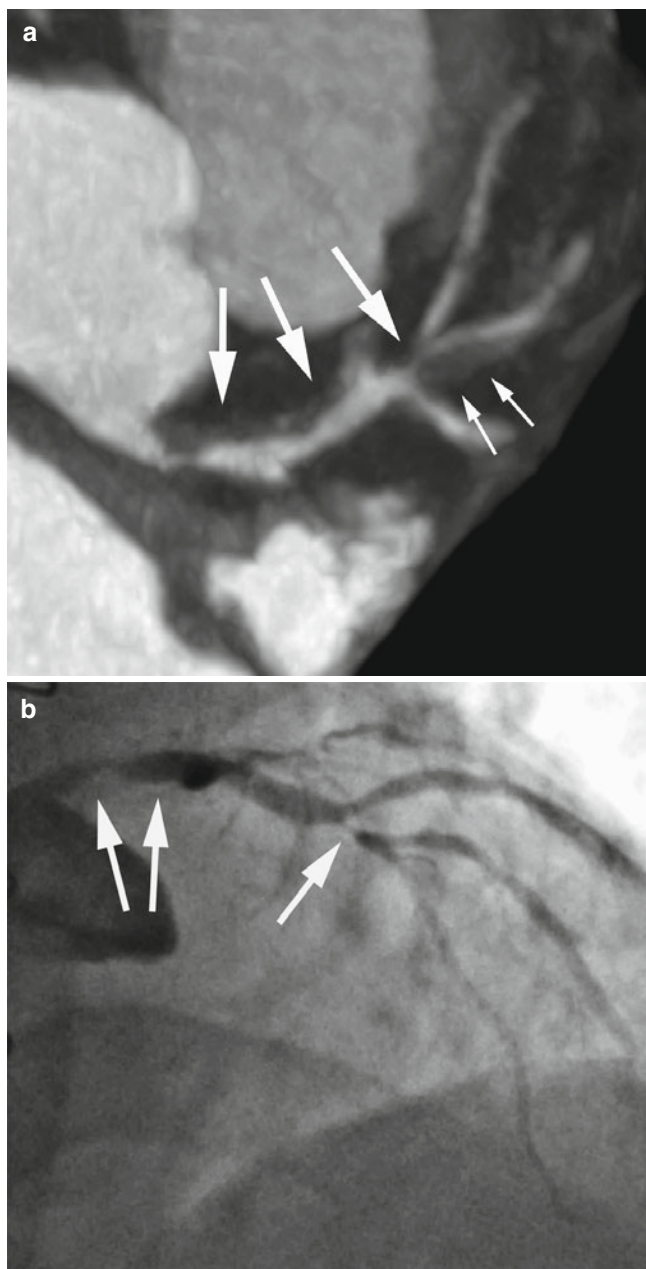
Exulcerated coronary atherosclerotic plaque. (a) and (b) Coronary CT angiography (64-slice CT) of the proximal left anterior descending coronary artery. A non-calcified plaque with a contrast-enhanced cavity is visualized (*large arrows*). This corresponds to an old plaque rupture that left behind an ulcerated plaque. The *small arrows* indicate some misalignment artifacts in the mid and distal left anterior descending coronary artery. (c) Invasive coronary angiograms that confirm the ulcerated plaque, now causing a moderate coronary artery stenosis (*arrow*)
